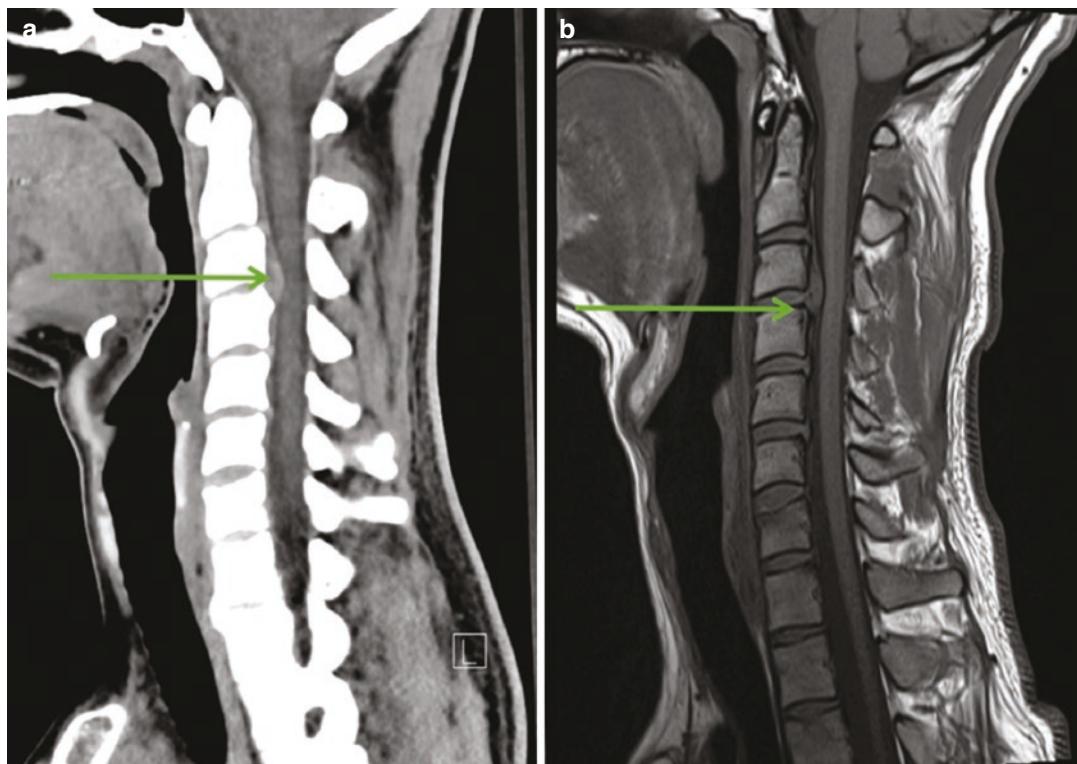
27 year-old male with history of fall to the ground during a soccer game. (a) Sagittal CT cervical spine image in soft-tissue window and (b) sagittal T1W
